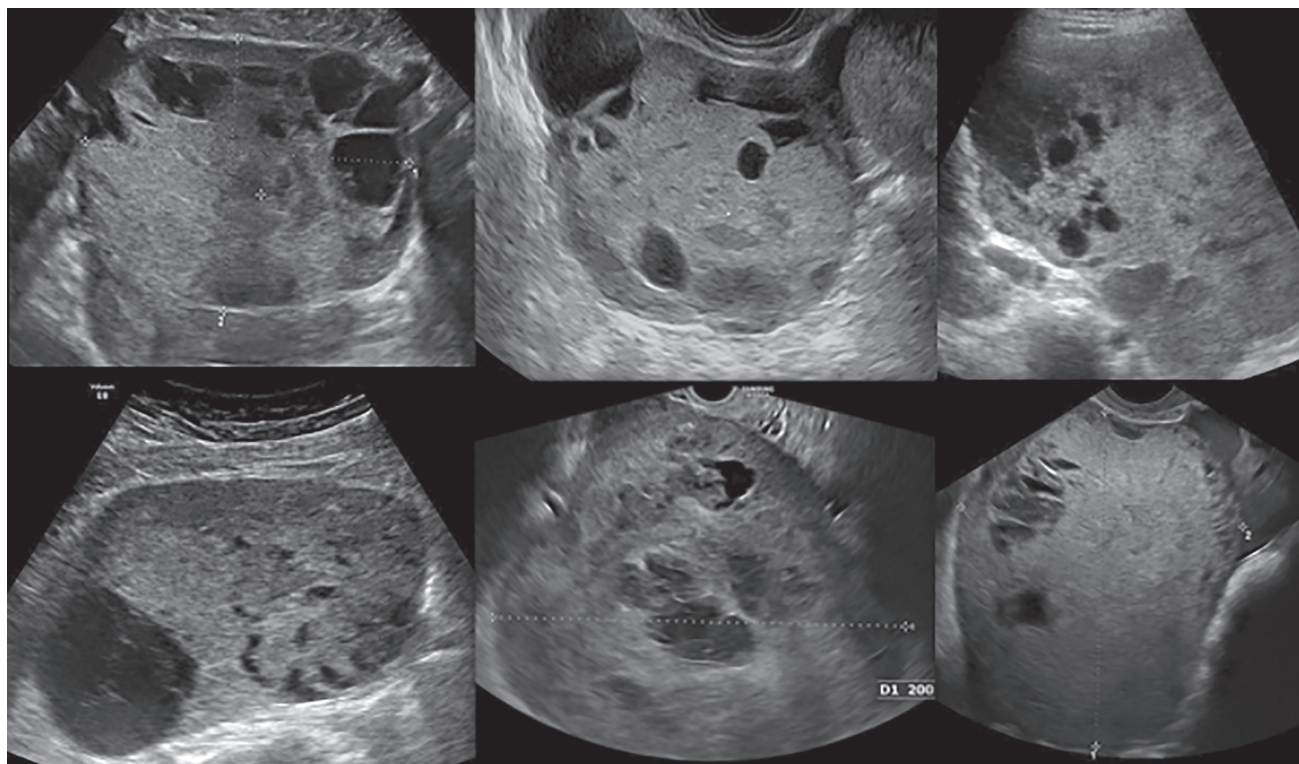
Ultrasound images of six different solid ovarian yolk sac tumors.
